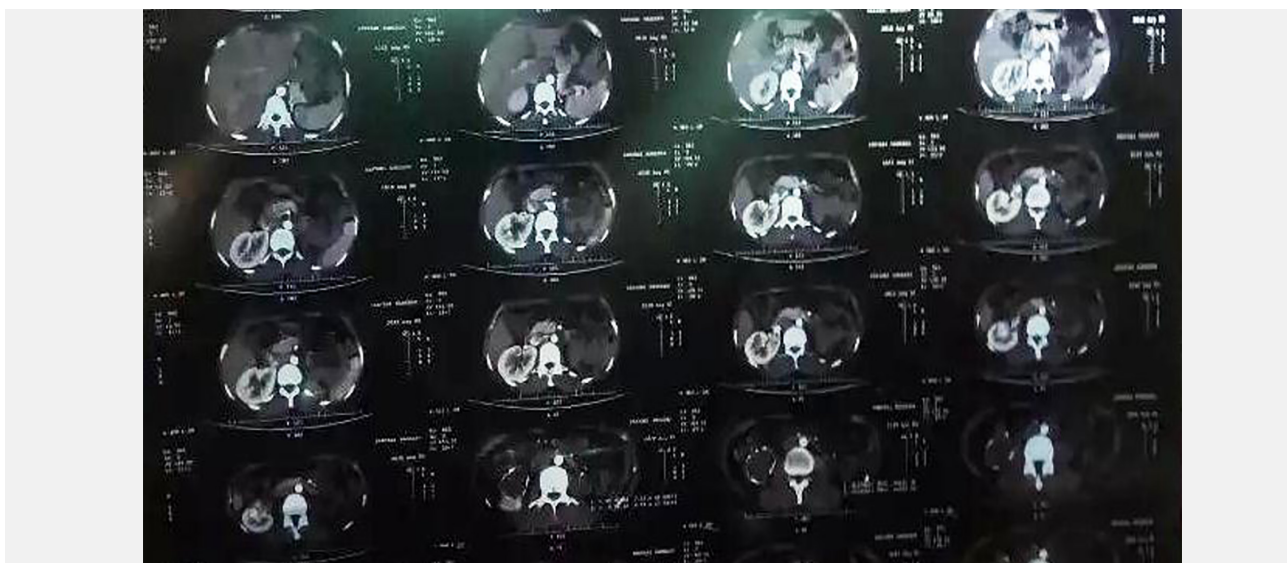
Right lower moiety dysplasia and left non-functional kidney on contrast CT scan
